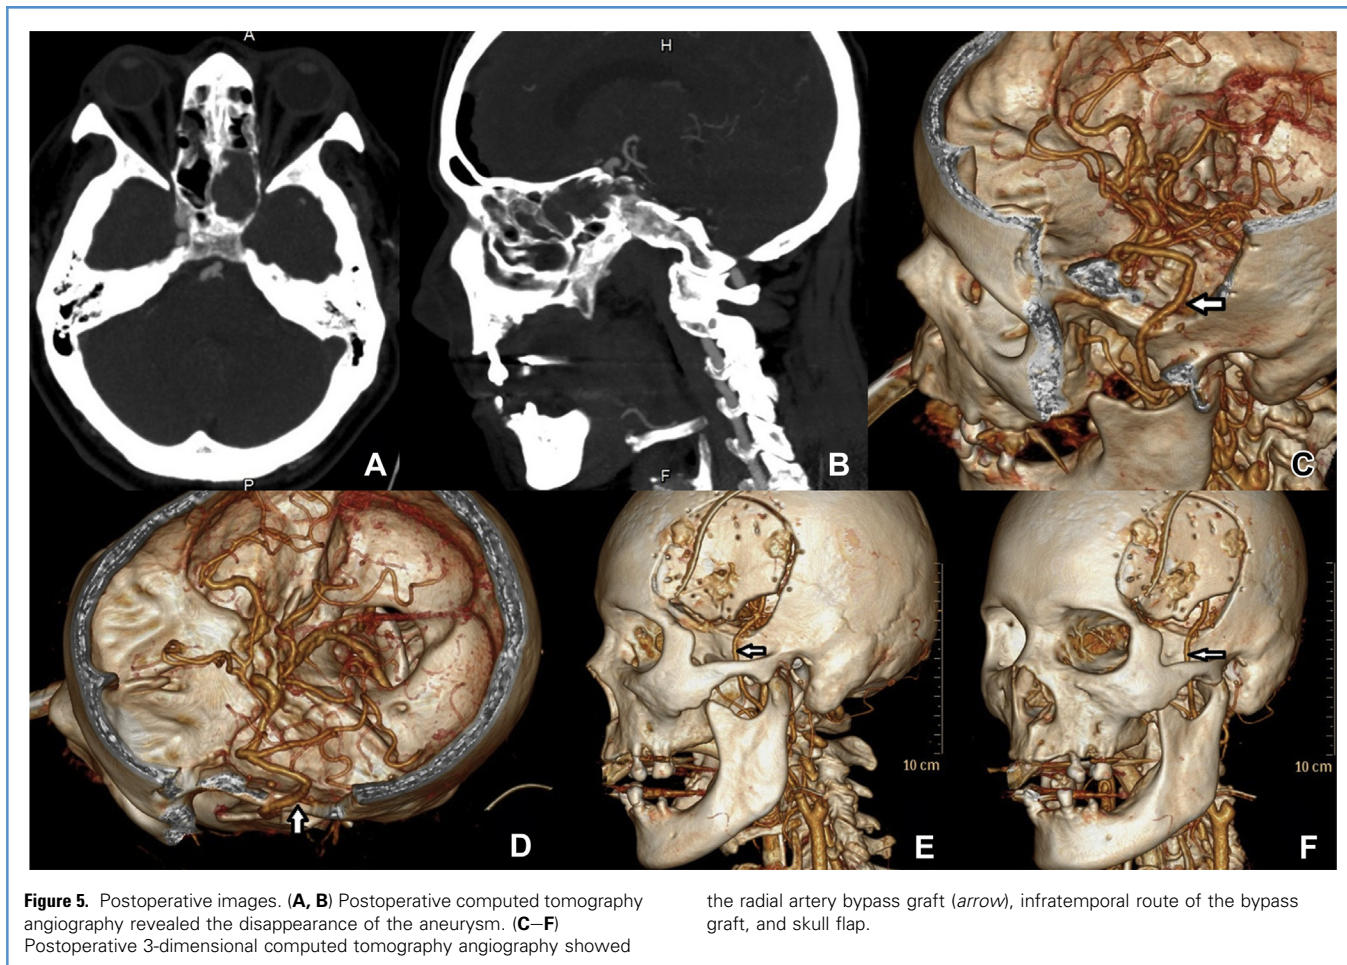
Postoperative images. (A, B) Postoperative computed tomography angiography revealed the disappearance of the aneurysm. (C–F) Postoperative 3-dimensional computed tomography angiography showed
